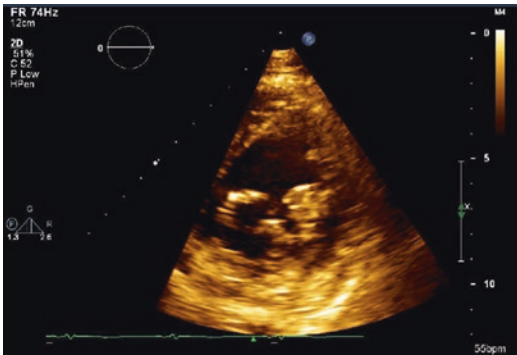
Echocardiographic imaging of a mitral valve showing a double orifice mitral valve
